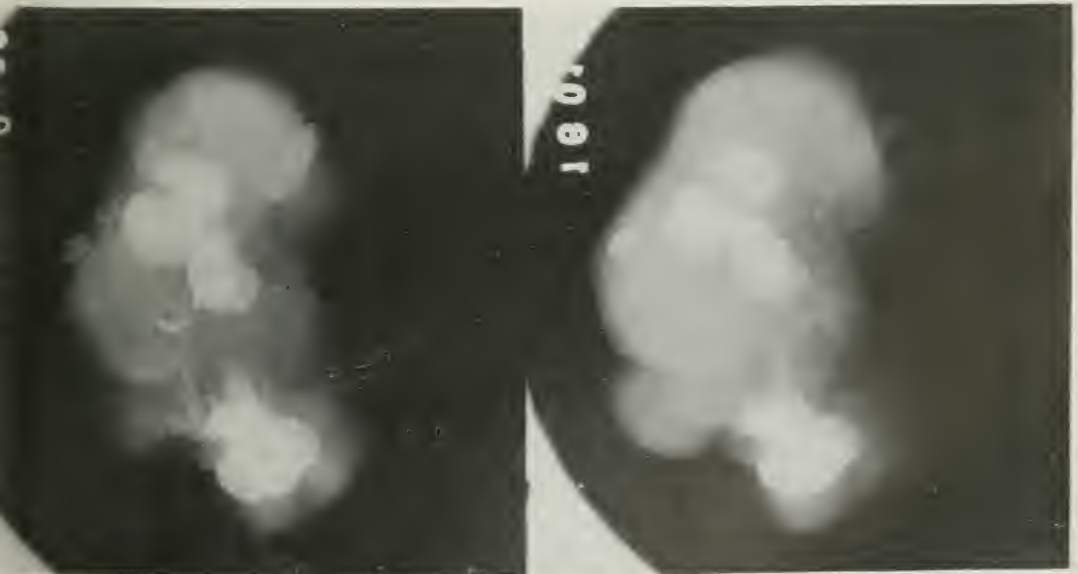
PYONEPHROSIS WITH STONES. NO PREVIOUS X-RAY EXAMINATION
